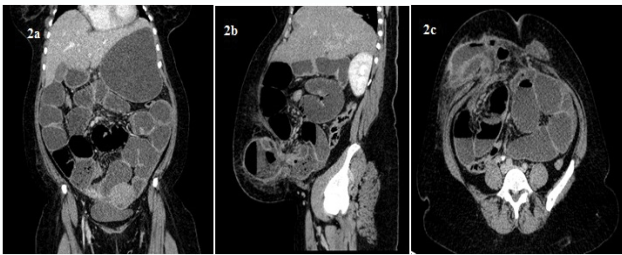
Contrast enhanced CT scan sagittal (a), coronal (b) and axial (c) images demonstrating dilated small bowel loops with air fluid levels, some loops are herniating through lower right para-midline anterior abdominal wall defect inferior and lateral to the umbilicus [Spigelian hernia] resulting into mechanical small bowel obstruction.
